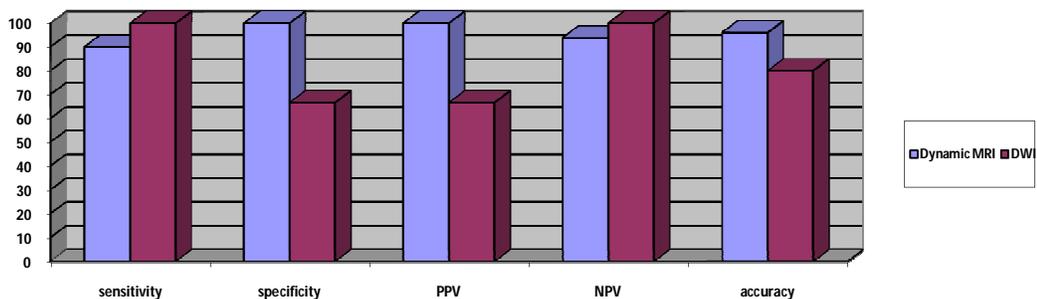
The different indices of the Dynamic MRI and DWI in post-TACE lesions.
